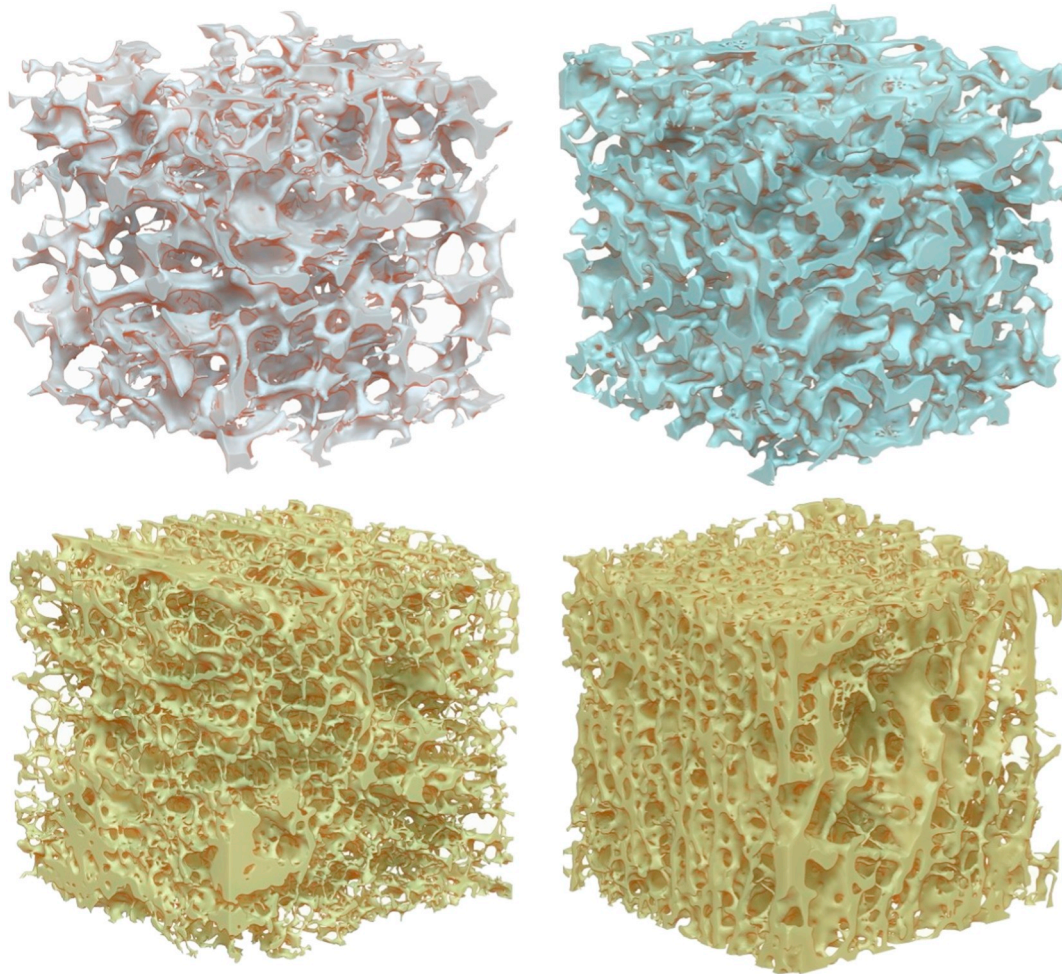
3D virtual μ CT reconstructions of cubic macro-VOIs with a size of $15 \times 15 \times 15 \text{ mm}^3$ for the samples analysed: top left (in white colour): White Foam (WF); top right (in blue colour): Blue Foam (BF); down left and down right (in yellow colour): central and peripheral area, respectively, of lumbar vertebra ESA (Ref. [34]). (For interpretation of the references to colour in this figure legend, the reader is referred to the web version of this article.)
